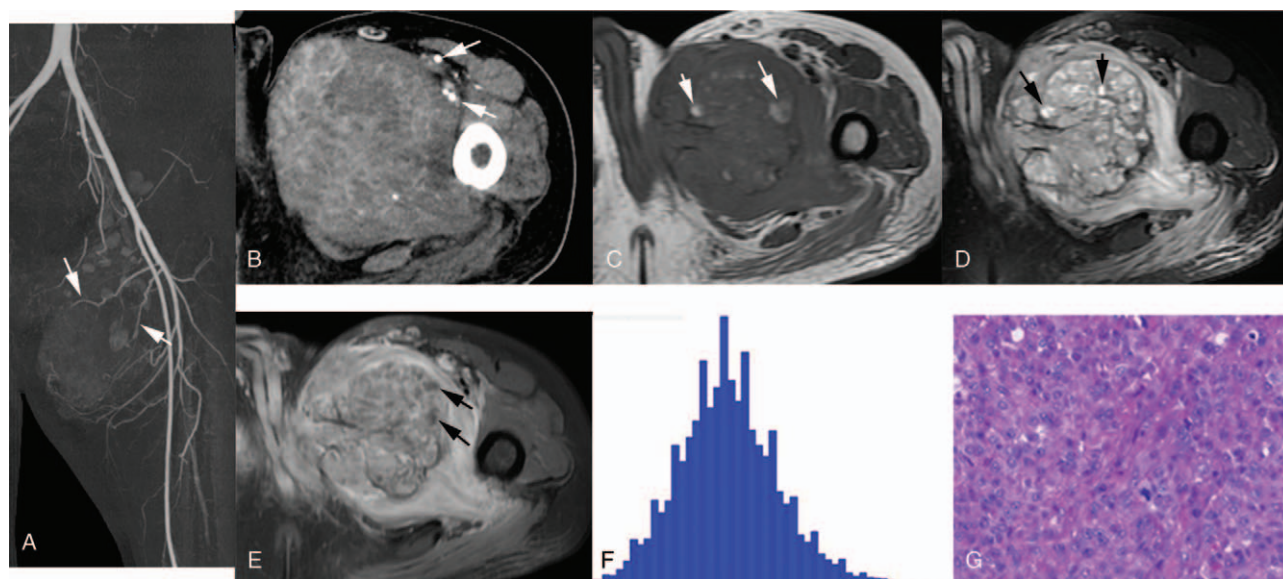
A 40-year-old man with a large soft tissue mass in the left thigh. Feeding arteries were well-depicted on maximum intensity projection CTA images (A, arrows). The tumor boundaries were not well-depicted on CTA source images (B), but the images clearly demonstrate tumor displacement of the regional arteries (B, arrows). Intra-tumor hemorrhage is seen on the T1-weighted MR images (C, arrows), while necrosis is better visualized on the T2-weighted images (D, arrows). Tumor enhancement was heterogeneous (E). Contrast-enhanced T1-weighted images also showed multiple areas of necrosis (E, arrows). Kurtosis, skewness, and inhomogeneity derived from the histogram (F) were 0.94, 0.79, and 0.42, respectively. The pathology showed an epithelioid sarcoma (G).
